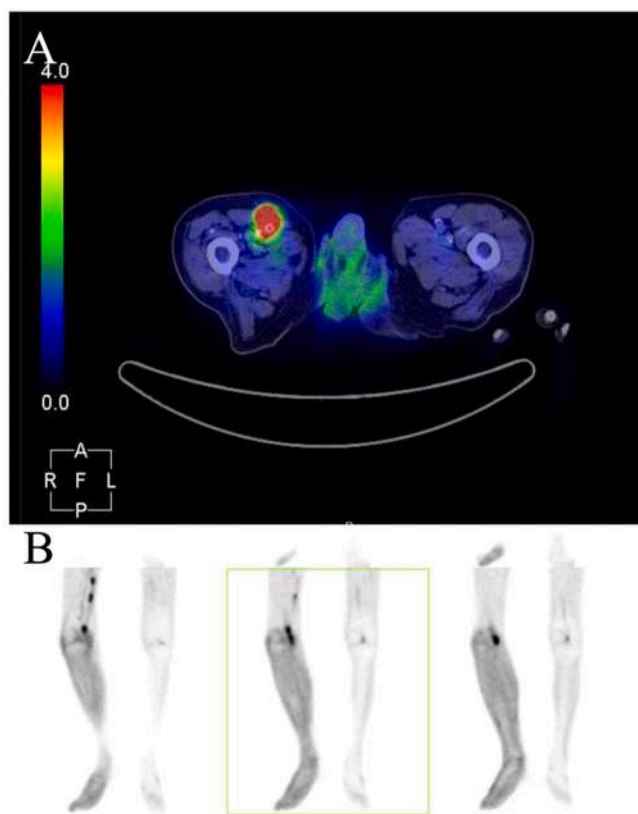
PET-CT scan. The FDG uptake confirms infection extending from the proximal (A) to the distal part (B) of the previous femoropopliteal bypass.
